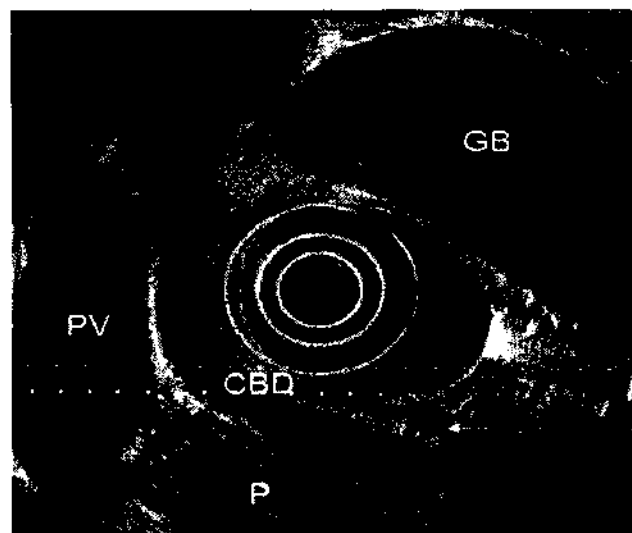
Endoscopic ultrasound of the pancreas. CBD, common bile duct; GB, gallbladder; P, pancreas; PV, portal vein.
